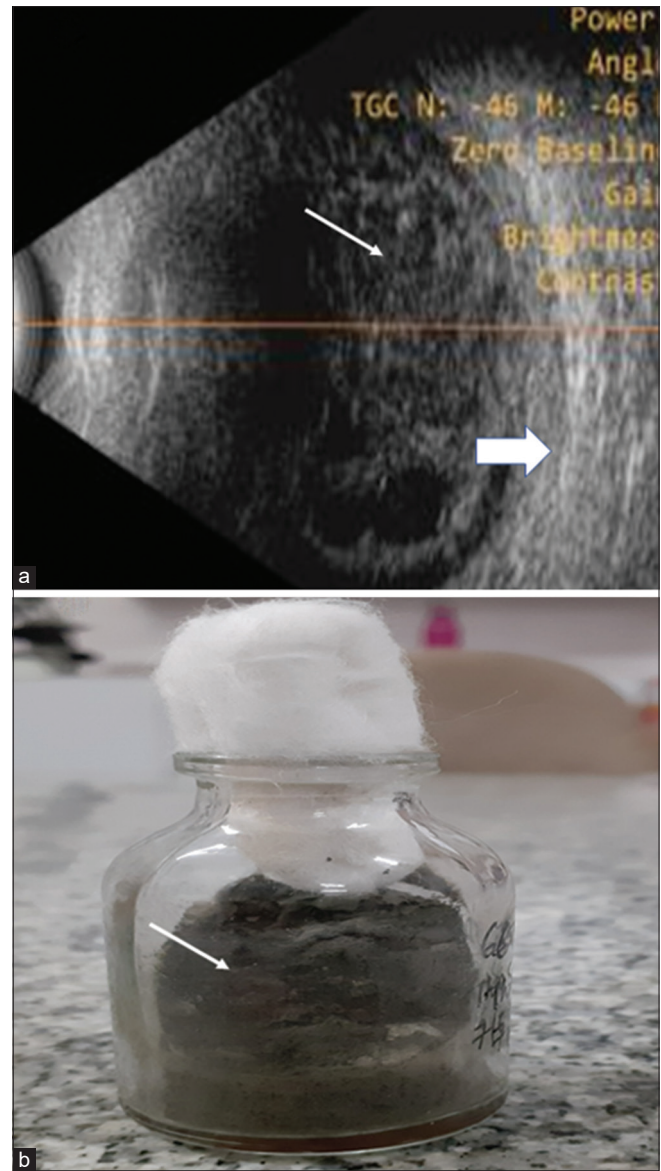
(a) Ultrasound B scan transverse section, showing moderately reflective dense echoes in the vitreous cavity (white arrow) with thickened chorioretinal complex (white thick arrow); (b) Sabouraud Dextrose Agar bottle showing the confluent growth of fungus (white arrow)
